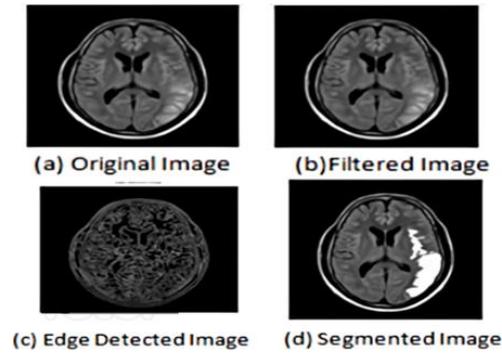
Steps in getting MRI images ready for use (a) the original image, (b) the filtered image, (c) the edge-detected image, and (d) the segmented image.
